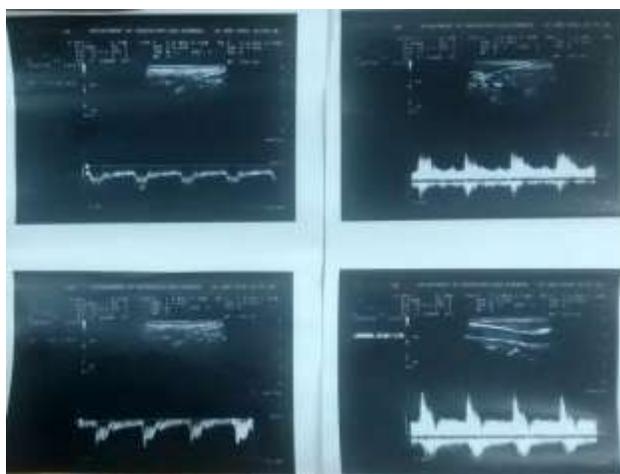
Carotid Doppler showing normal study
